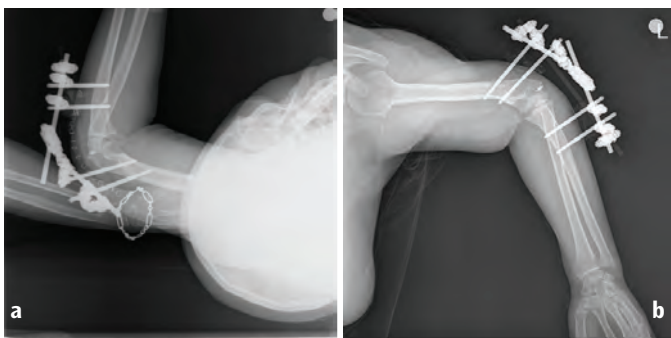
a, b) Postoperative X-rays of one of our patients
